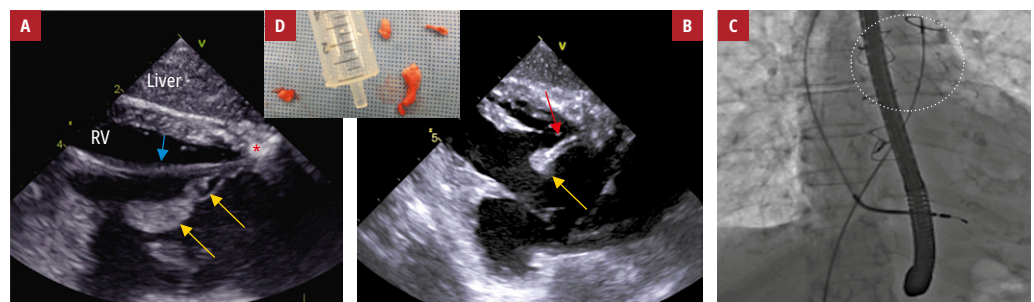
Transesophageal echocardiography monitoring of the aspiration of a vegetation attached to the lead and the tricuspid valve using the TM Penumbra Inc. system and pulmonary embolism protection during transvenous lead extraction: A – lead-related infective endocarditis and vegetations visible on the high-voltage lead (blue arrow) in the right ventricle (yellow arrows) attached to the lead and the tricuspid valve (red asterisk); B – aspiration of the vegetation using the TM Penumbra Inc. system under transesophageal echocardiography guidance (2-dimensional, transgastric view); C – simultaneous fluoroscopic image showing a nitrile basket (circle) in the pulmonary trunk to protect the pulmonary circulation; D – vegetations
